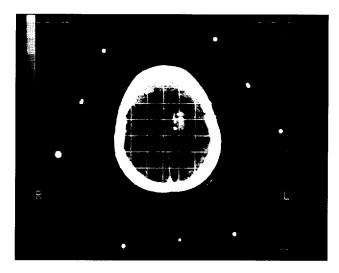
Transverse CT scan of the patient with glioma in the left parietal region. Target in the centre of the grid with 9 fiducial points obtained by BRW stereotactic head ring and BRW localizer.
